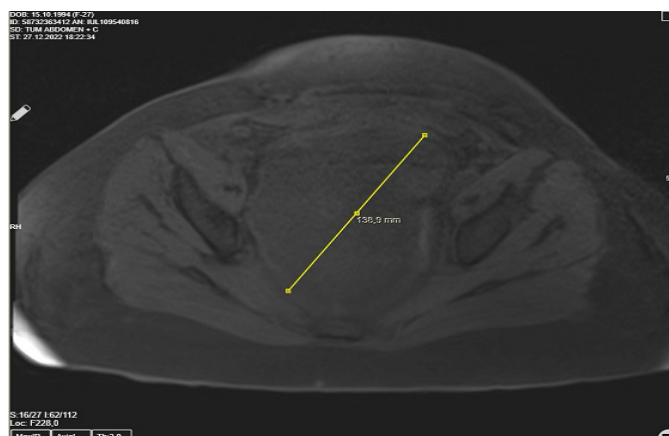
Magnetic resonance imaging showing a large heterogeneous pelvic mass (138×120 mm) compressing adjacent structures
